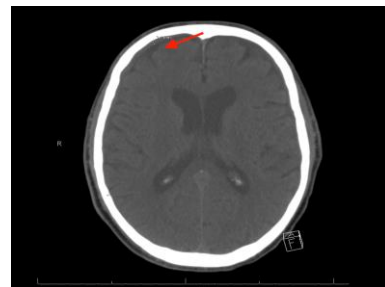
CT Head with Right Subdural Hematoma measuring 3.1 mm
